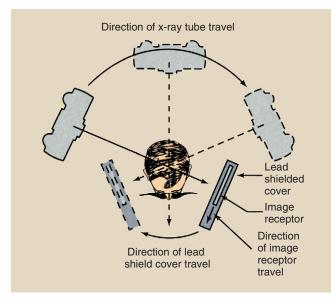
X-ray source-image receptor motion for panoramic tomography.
